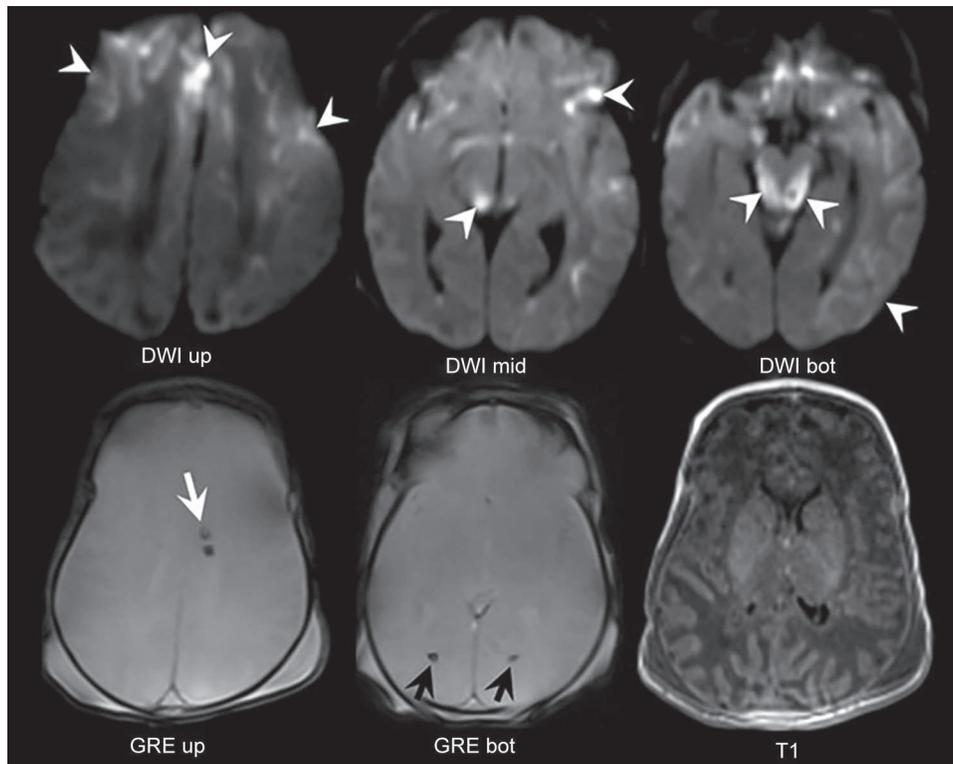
The top row shows axial DWI images of the brain at three different levels, the corresponding confirmatory apparent diffusion coefficient (ADC) maps are not shown. The arrowheads indicate areas of restricted diffusion involving the cortex of the bilateral cerebral hemispheres as well as the dorsal brainstem. There was also involvement of the right thalamus and the left cerebellar hemisphere (not shown). The bottom row shows Gradient Echo sequences at two different levels (left and middle panels), and an axial T1 image on the right inferior side. The GRE images show a left caudothalamic groove hemorrhage (white arrow), and a small amount of intraventricular hemorrhage pooling at the tips of the occipital horns of the lateral ventricles (black arrows). The axial T1 image shows normal myelination for the patient's age, with no abnormal signal of the cortical or deep white matter
